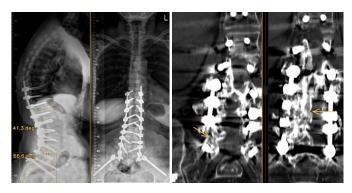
X-ray of the whole spine a.p and laterally in standing position and CT scan of lumbar spine after one year postoperatively show no loss of correction, no material failure and a good fusion
